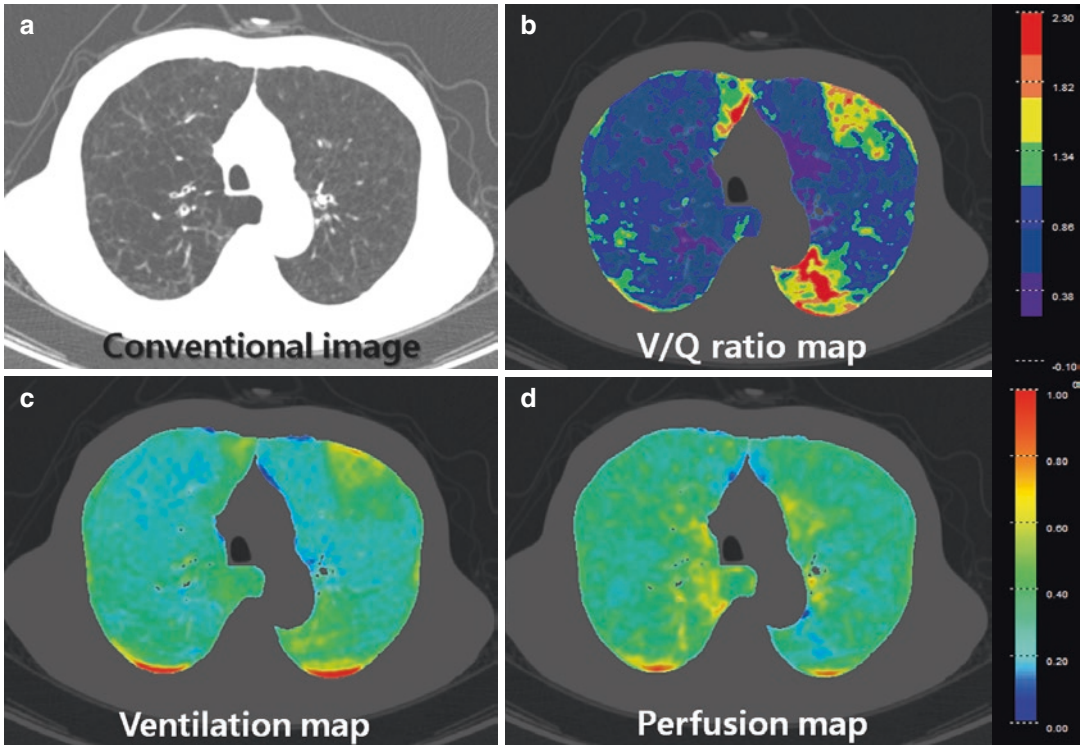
Combined ventilation and perfusion assessment with dual-energy CT. From combined xenon ventilation and iodine perfusion CT using dual-energy CT, the conventional virtual non-contrast CT image (a), xenon ventilation/iodine perfusion map (b), ventilation map (c)
